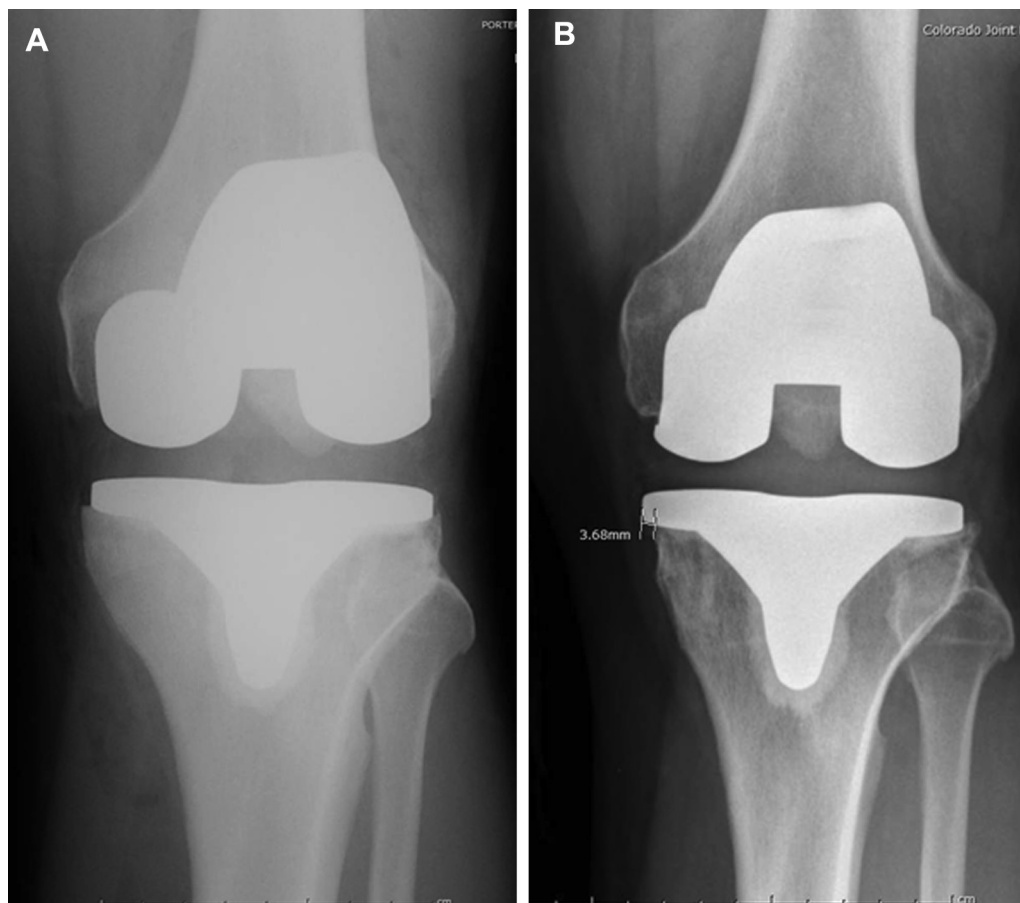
(A) Immediate AP knee postoperative radiograph showing no medial tibial baseplate overhang. (B) Two-year postoperative AP knee radiographs show approximately 4 mm of medial tibial bone loss below the tibial baseplate.
